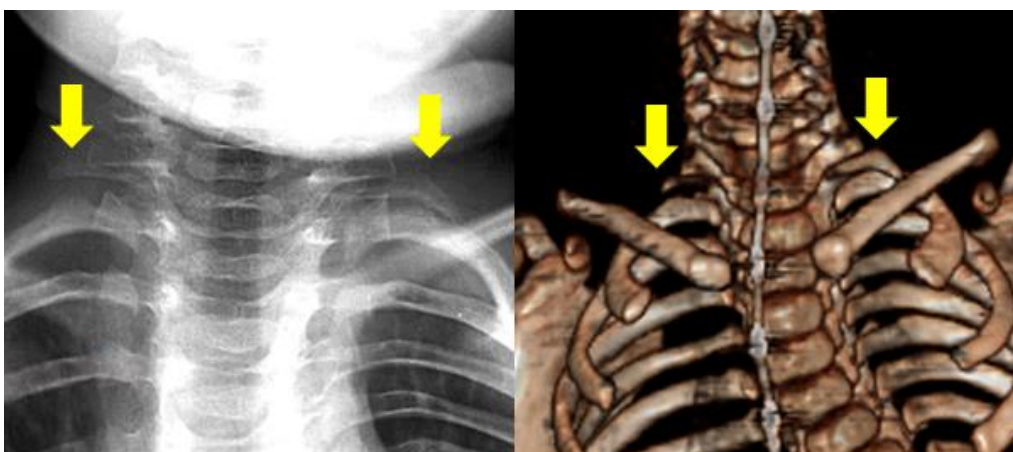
Radiograph (left) and 3-dimensional reconstruction of Computed Tomography image (right) showing bilateral rudimentary cervical ribs (arrows) in an infant born with an esophageal atresia.
